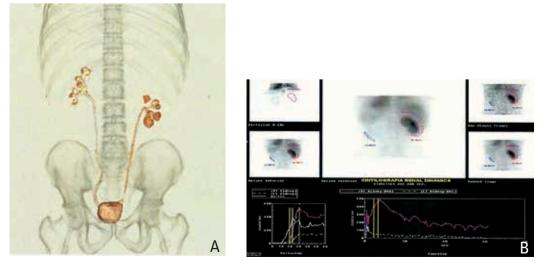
A and B - Renal scintigraphy shows a normal left kidney and a sharply hypoperfused right kidney
